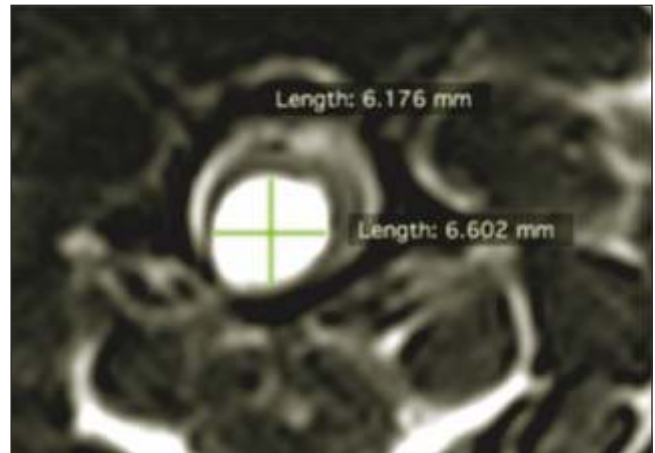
T2-weighted MRI images of the spinal cord, transverse plane. The internal diameter of the syrinx is greater than 2mm - Grade 2 SM. Note the syrinx asymmetry in both cases.
